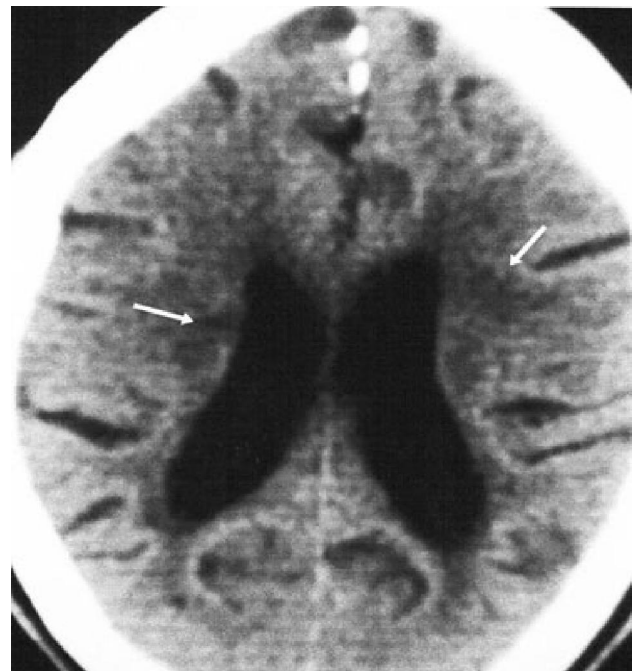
Non contrast axial CT Brain in a 33 year old HIV patient shows diffuse brain atrophy with symmetrical hypodense areas in the deep white matter periventricular in location-PML.
